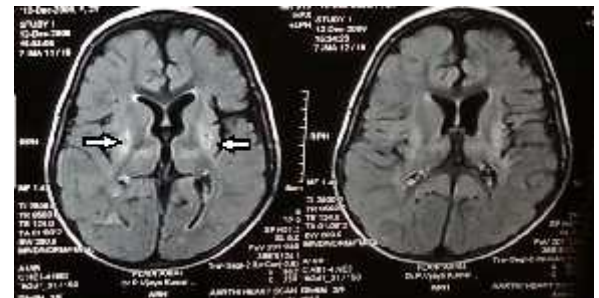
Bilateral Basal ganglia lesions – Axial FLAIR show hyperintensity in bilateral lentiform nucleus.
